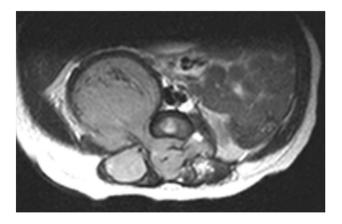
Axial MRI demonstrating neural foramina invasion by the neuroblastoma
